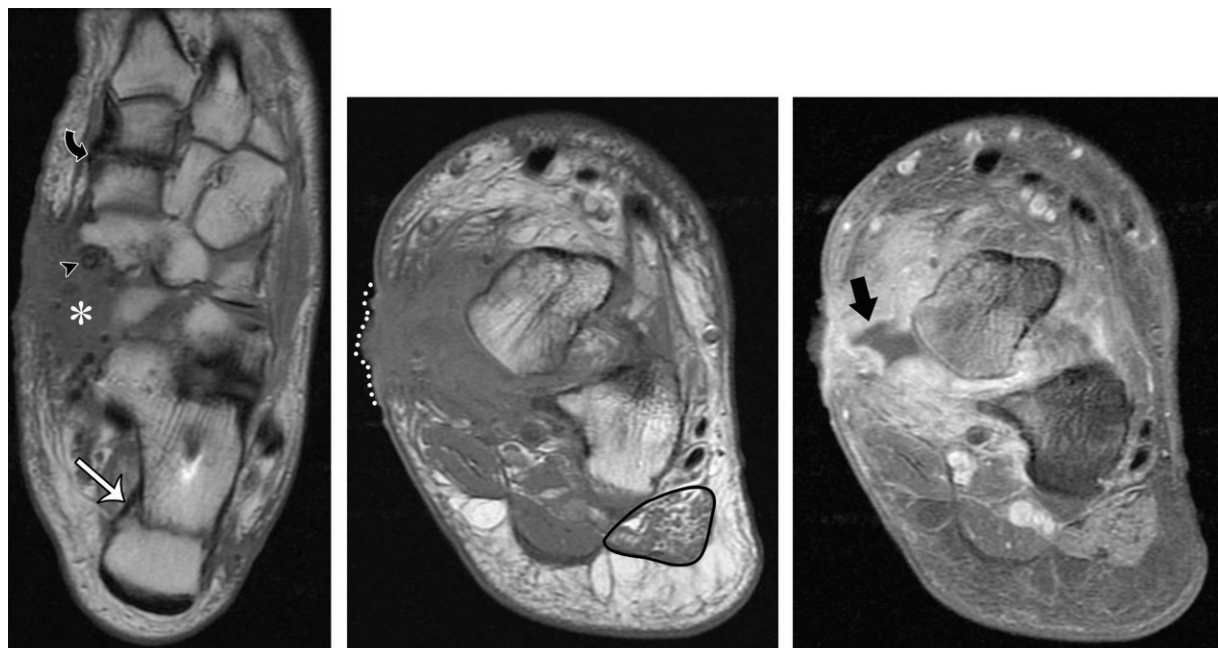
Postoperative infection in a 36-year-old man. (a) Axial T1-weighted MR image obtained after medializing calcaneal osteotomy (white arrow), medial cuneiform osteotomy (black arrow) and navicular anchor for soft-tissue reconstruction (arrowhead) shows extensive soft tissue at the medial foot (*) with loss of all normal soft-tissue structures. (b) Coronal T1-weighted MR image shows soft-tissue thickening at the surgical bed, with skin irregularity (dotted line) overlying the talar head, which shows subtle marrow alterations. Note the atrophy of the abductor digiti minimi muscle (outlined in black), which suggests denervation myopathy and is seen commonly in patients with advanced AAFD with plantar fascia degeneration. (c) Coronal contrast material-enhanced fat-suppressed T1-weighted MR image shows avid enhancement of the bone and soft tissues, with a nonenhancing collection of fluid (arrow) that was draining at the skin medial to the talar head.
